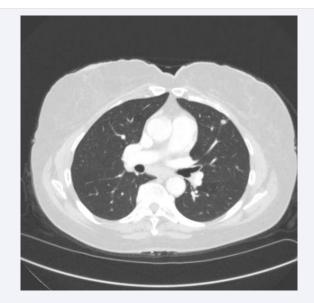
Axial non-contrast CT of the depicts an 8 mm left upper lobe pulmonary nodule. Lungs are otherwise well expanded with no other suspicious pulmonary nodules, masses, or pleural fluid collections.
